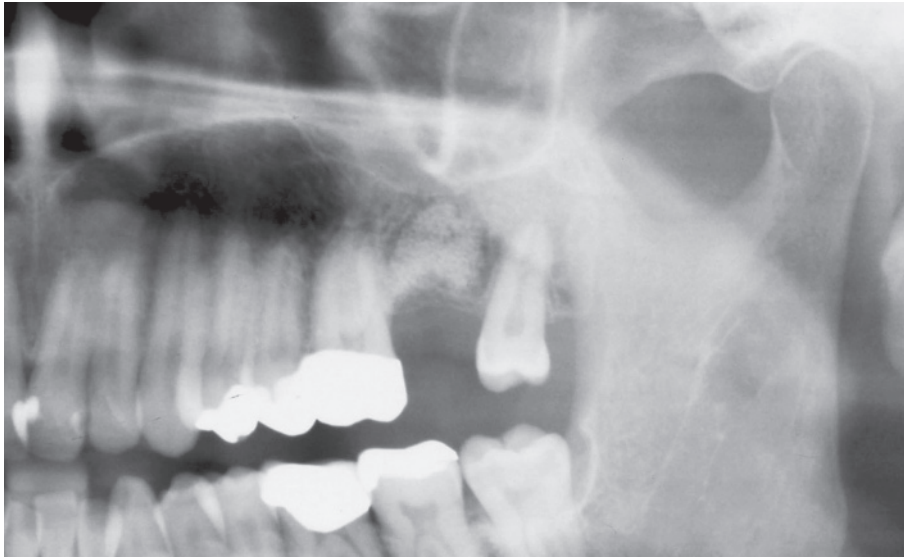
Detail of orthopantomographic image. Alveolus filled with Cerasorb® in region 27.
